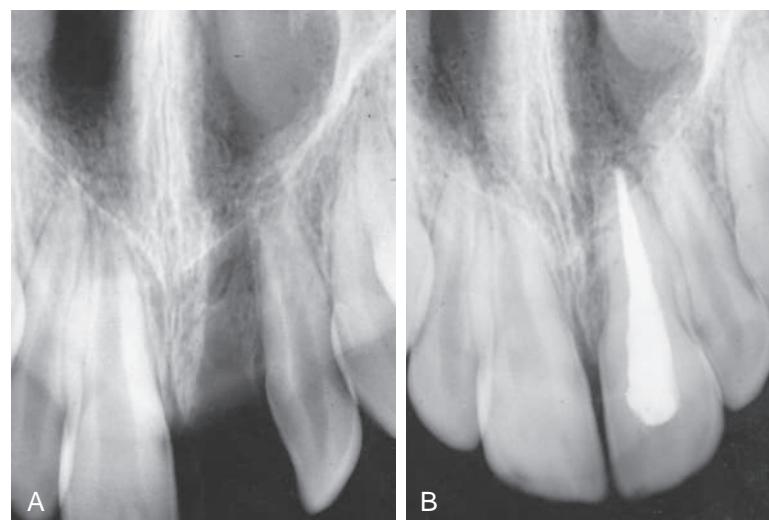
(A) Radiograph of a patient who lost a central incisor as the result of trauma. Replantation was performed. (B) After the replantation procedure, peripheral root resorption is evident along the mesial surface.
